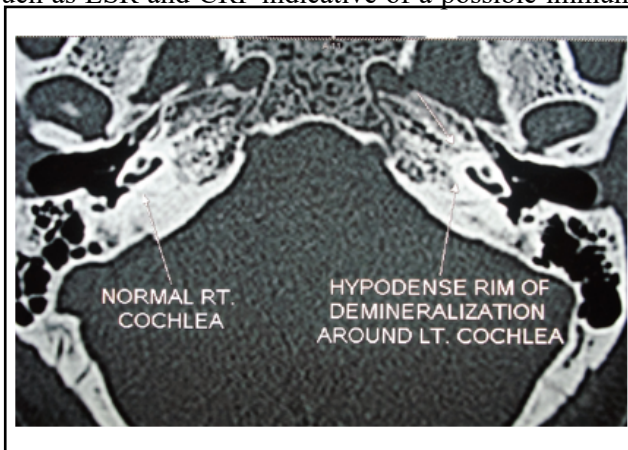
Axial HRCT image of patient no 2 showing circumferential rim of hypolucency in pericochlear region on (L) side only
